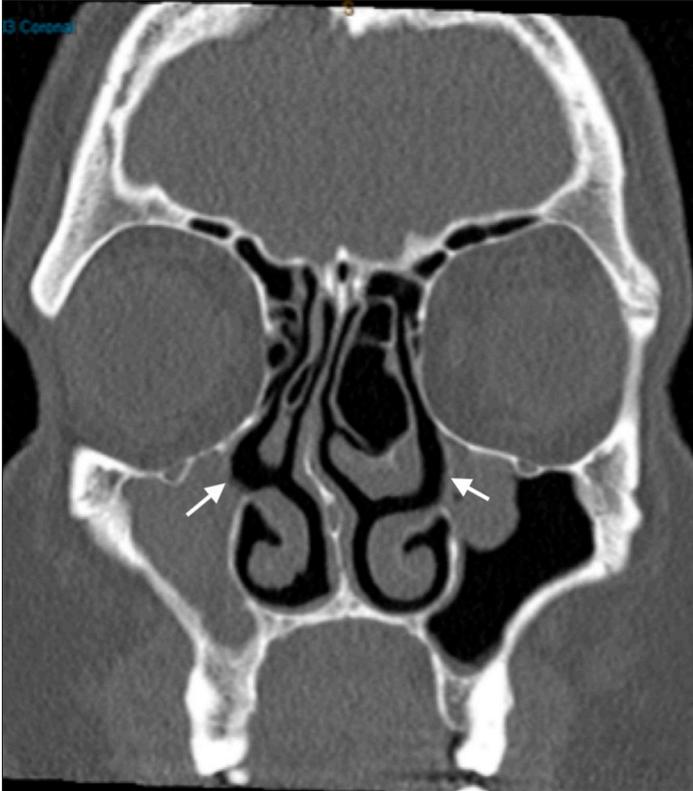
Coronal view of a CT scan of the paranasal sinuses demonstrating septal deviation to the right, bilateral lateralization of uncinate processes, a large left concha bullosa, bowing of the superior osseous walls (right more pronounced than left), opacification of the right maxillary sinus and an early retention cyst in the left maxillary sinus
